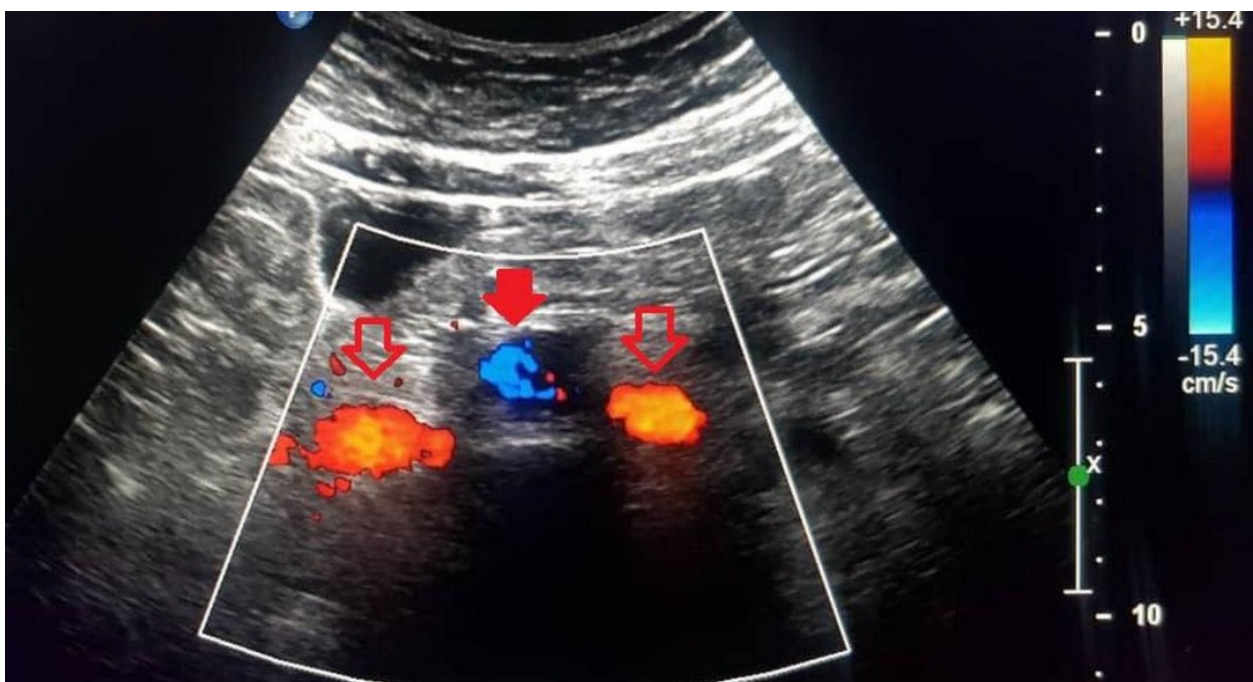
Abdominal color Doppler ultrasound showing the aorta in the center of the image with a closed arrow and double IVC on both sides of the aorta with two open arrows
